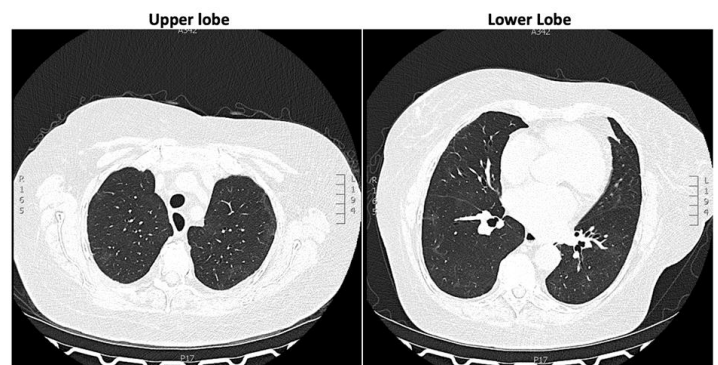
High-resolution CT (May 2025) demonstrating persistent fibrotic changes despite partial resolution of acute infiltrates.
